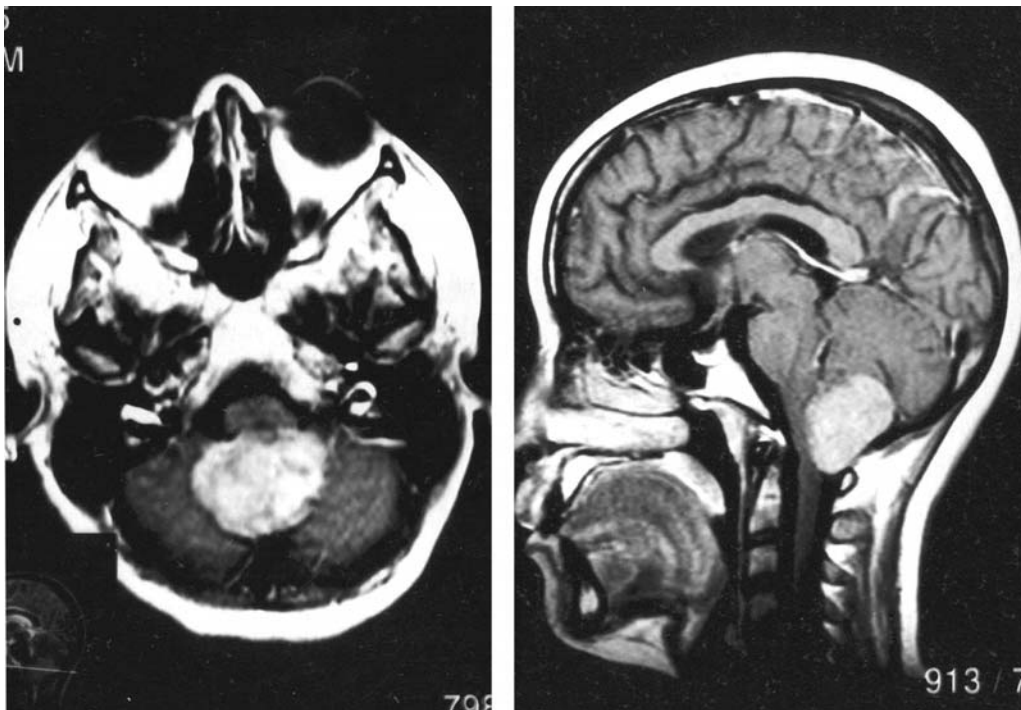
Gadolinium enhanced T1-weighted MRI showing an enhancing mass in the inferior region of the fourth ventricle and foramen magnum
